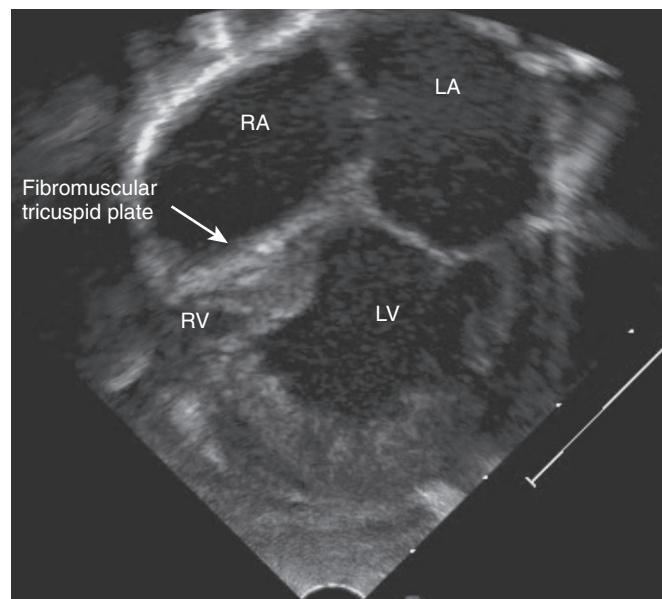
Apical four-chamber view on echocardiogram of a neonate with tricuspid atresia. There is no tricuspid valve with a fibromuscular plate in its usual place. A large atrial septal defect permits flow from the right atrium (RA) to the left atrium (LA) and into the left ventricle (LV). The right ventricle (RV) is severely hypoplastic.
